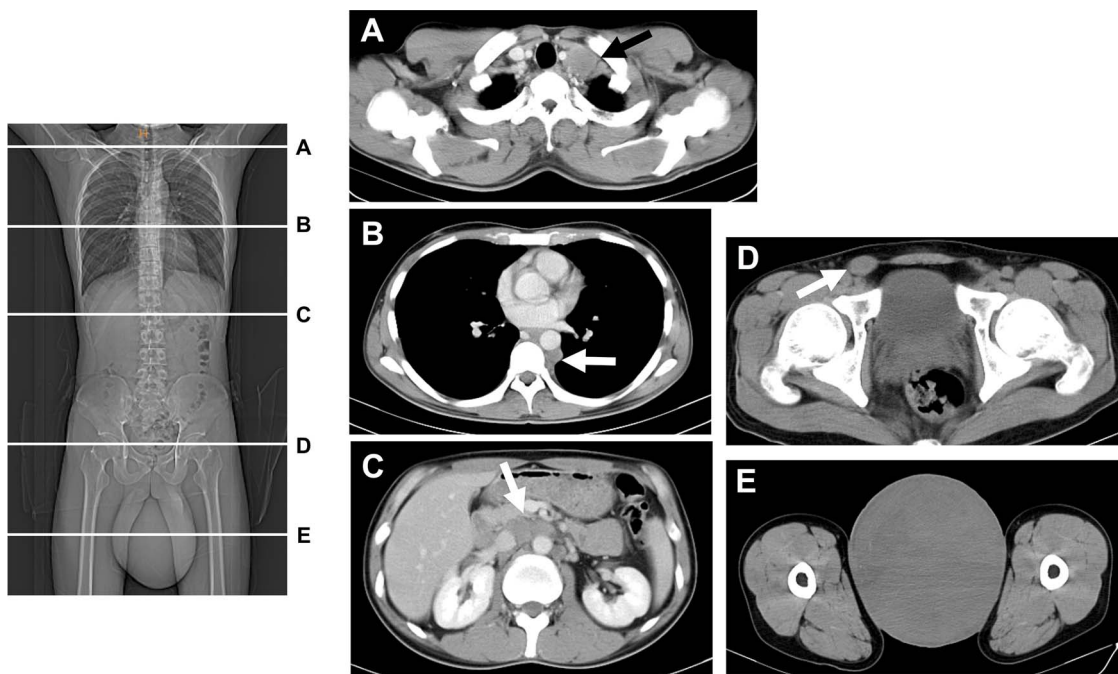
Computed tomography scan at the first visit. (A, B, C) Contrast-enhanced images of lymph node metastases. (D, E) Primary tumor of the right testis and spermatic cord. Only plain images were available. The arrows indicate the tumors.
